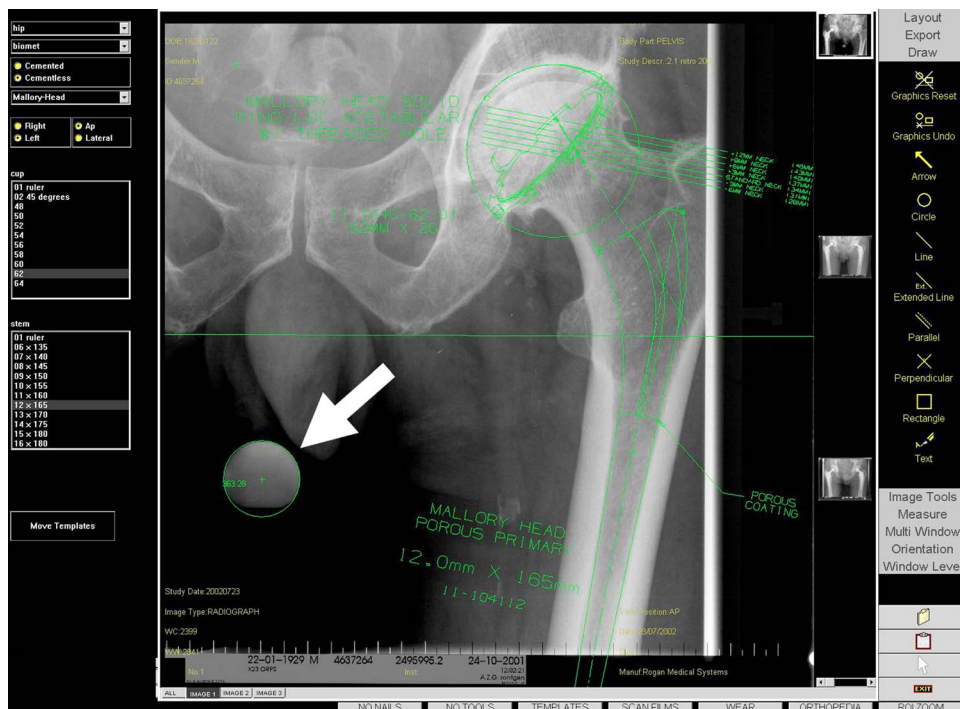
A magnified part of a digital plain pelvic radiograph on which a preoperative plan for total hip arthroplasty has been constructed. The calibration object (arrow) is positioned between the legs of the patient.
